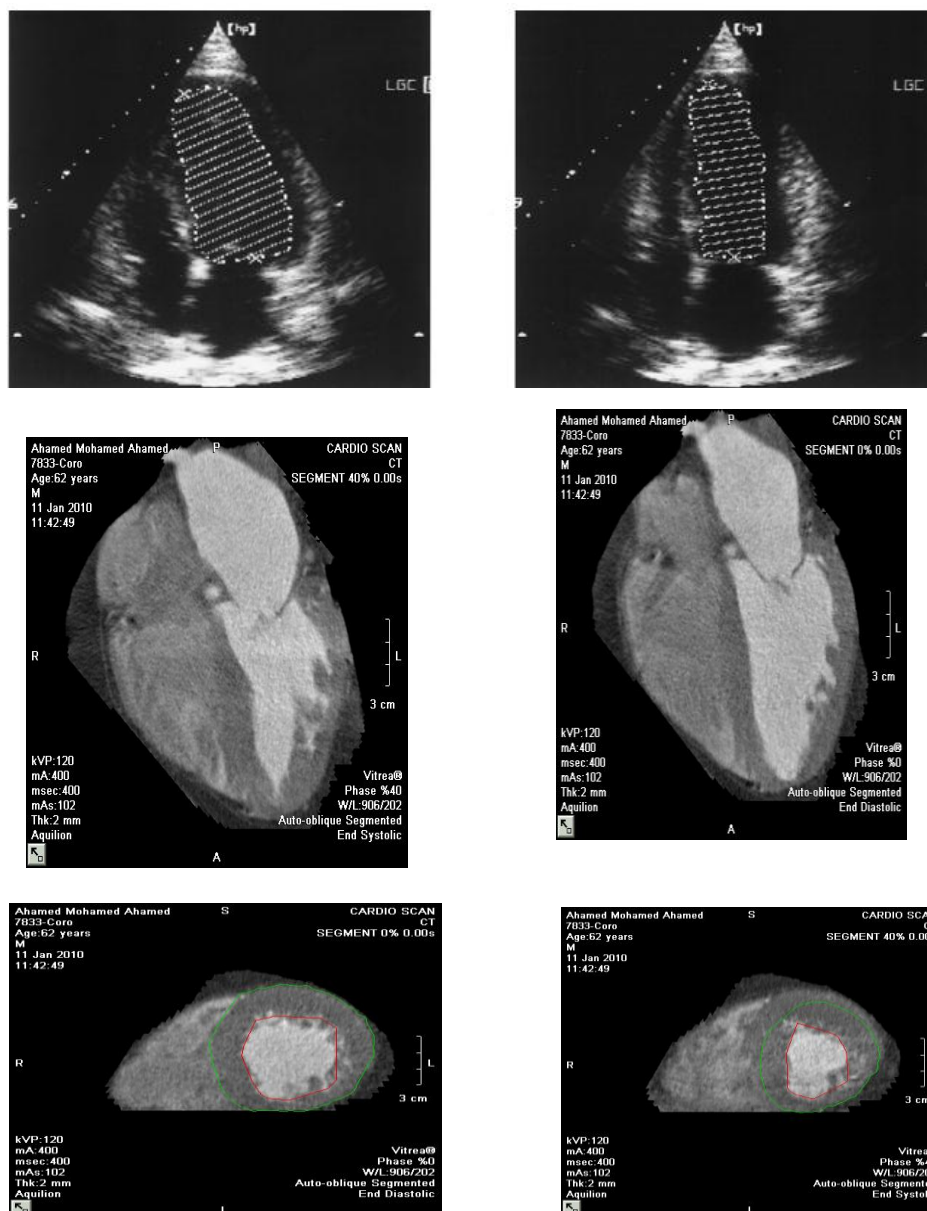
(case No. 17) upper panel shows EF estimation by 2D Simpson's BP apical 4-chamber method. Middle and lower panels show corresponding MSCT estimation of LVEF of one case of the study. Estimated EF was 38% by MSCT and 37% by 2D echo.
